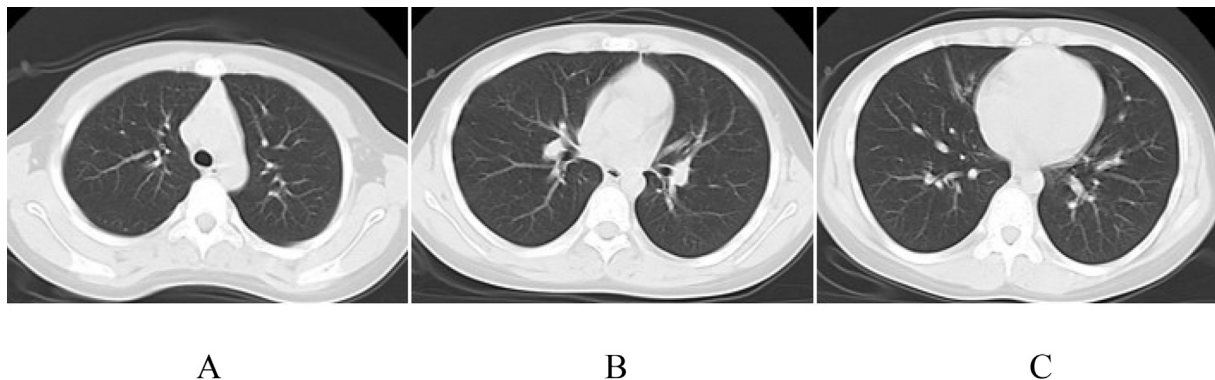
Chest CT on the first day after admission showed there was cord shadow in the middle lobe of the right lung, and no obvious abnormality was found in the remaining part of the lung.
